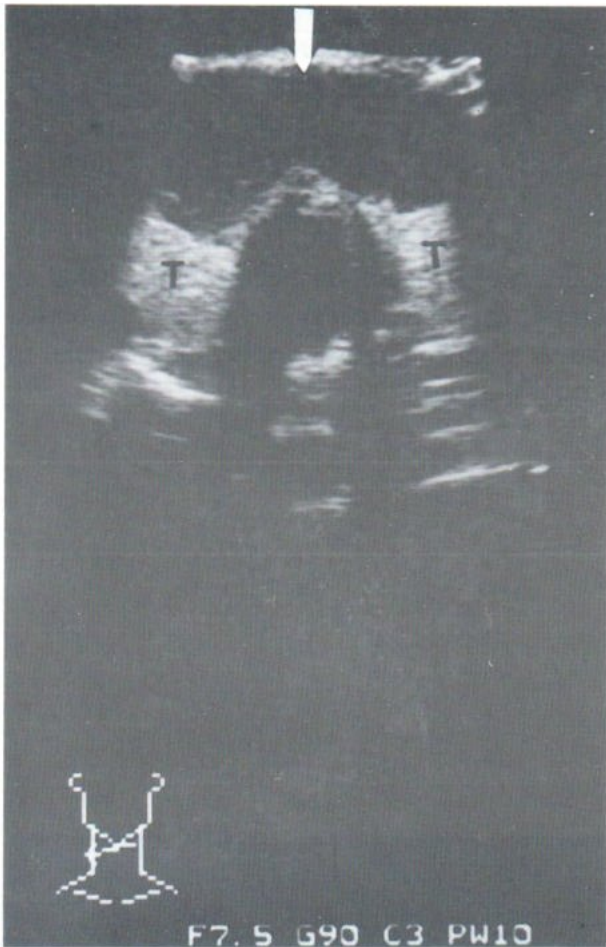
Transverse ultrasound image of the neck shows an abscess (arrow) anterior to both lobes of the thyroid gland (T).
